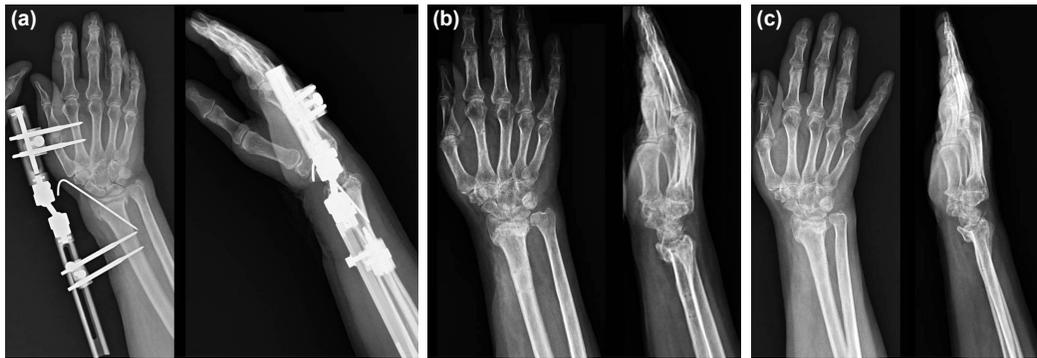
Radiological evaluation of the patient after the operation. (a) Two-planned radiographs obtained on the first day after closed reduction and external fixation supported with a K-wire. (b) Fracture healing on standard wrist radiographs obtained 3 months after operation. (c) Standard two-sided wrist radiographs obtained 2 years after treatment.
